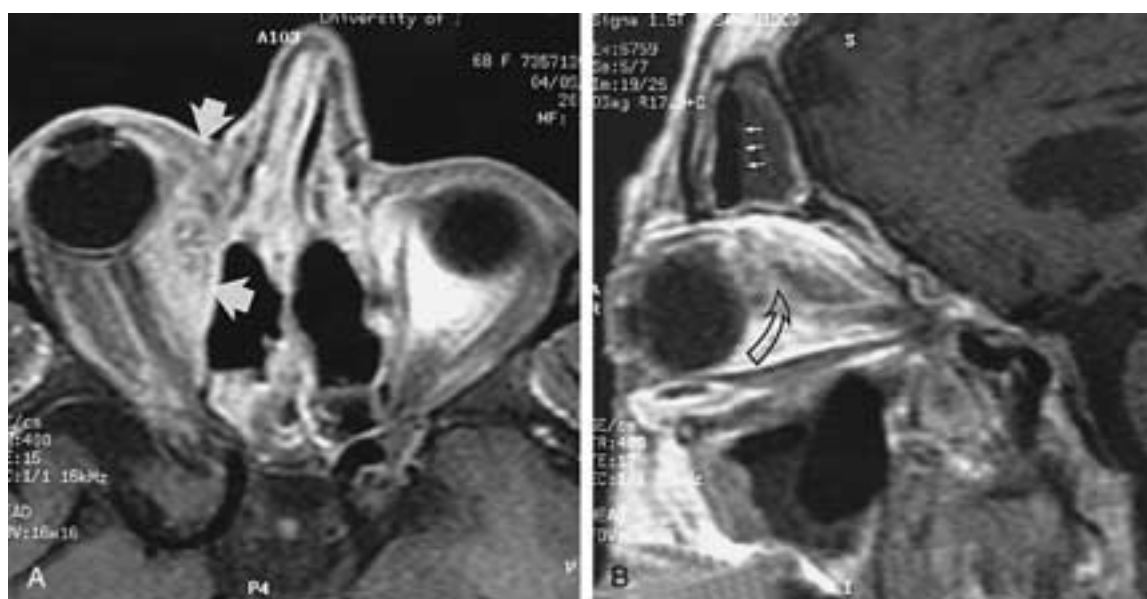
Orbital cellulitis. A, Enhanced, fat-suppressed, axial T1-weighted MR image showing diffuse enhancement of pre- and postseptal orbital tissue (arrows). B, Enhanced, fat-suppressed, sagittal T1-weighted MR image shows an air-fluid level in the frontal sinus (arrows) and diffuse orbital enhancement (curved arrow). There is no orbital abscess formation. (From Eustis HS et al. MR imaging and CT of orbital infections and complications in acute rhinosinusitis. Radiol Clin North Am 1998;36:1165-1183.)
